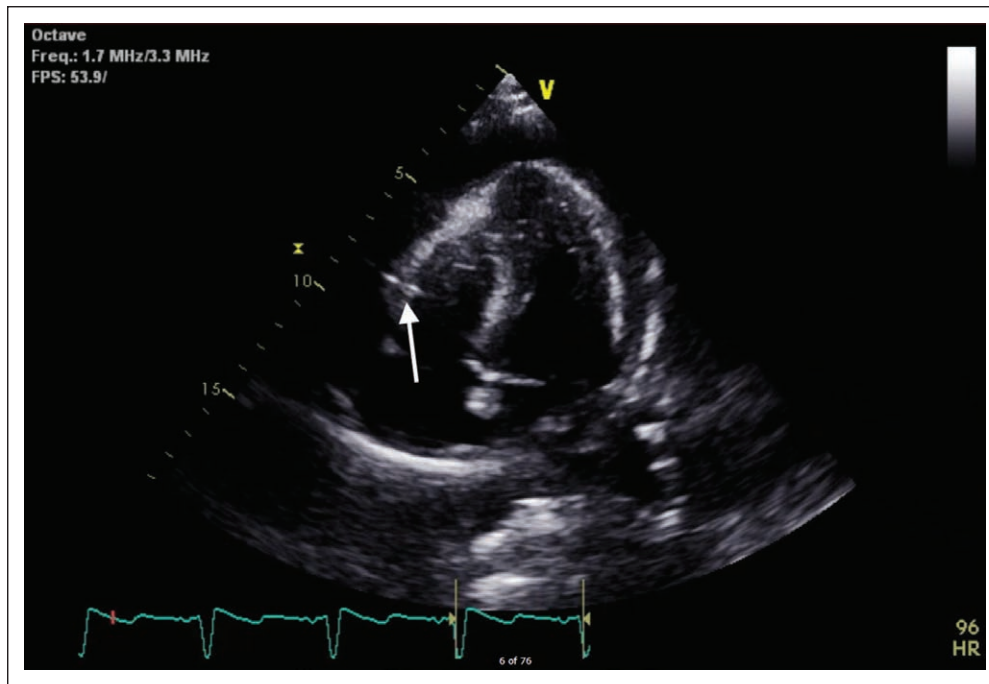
Transthoracic echocardiogram in the apical four chamber view with the echogenic needle in the right ventricle penetrating the myocardium into an observed pericardial effusion. FPS = frames per second, HR = heart rate.
